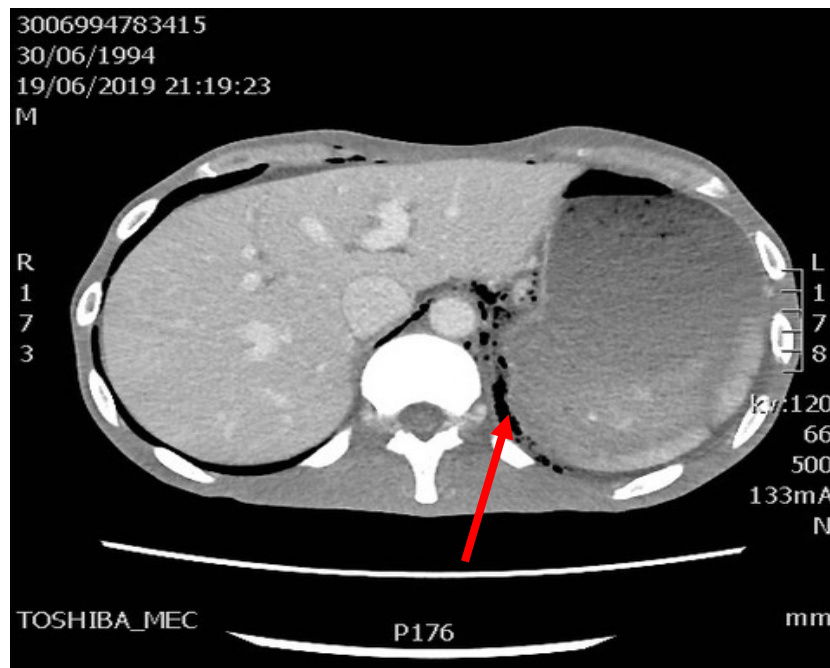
Computed tomography scan shows pneumoretroperitoneum (red arrow indicates change).
